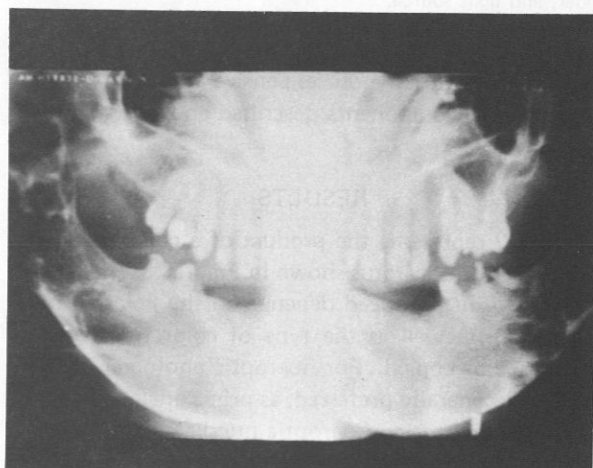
Panorex radiograph demonstrating multilocular radiolucent lesion of mandible.
